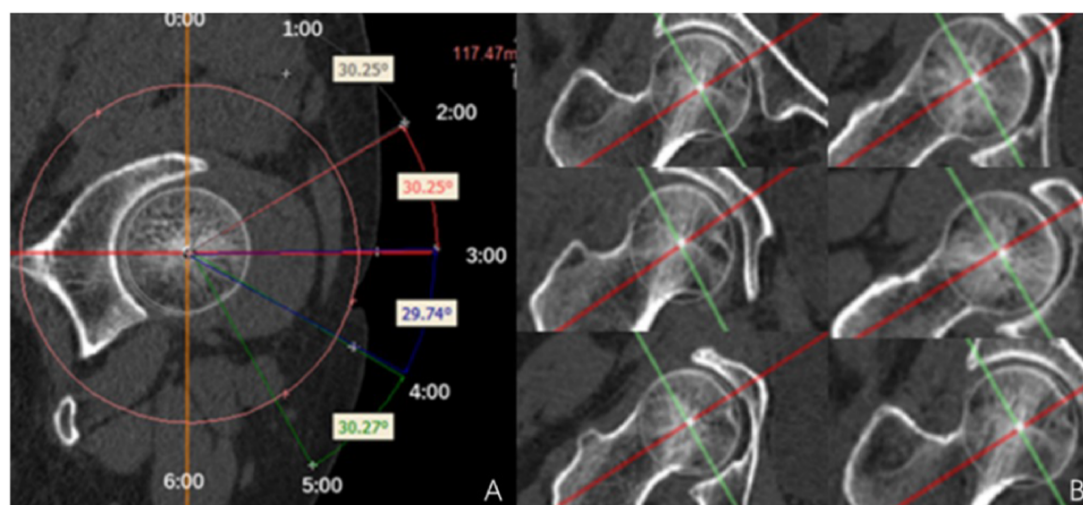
Example of multiplanar reconstruction of a hip joint CT image. (A) The hip CT images were reconstructed based on plane A. (B) Different hip planes were acquired. The α angle of 1:00, 2:00 and 3:00 positions was measured.
